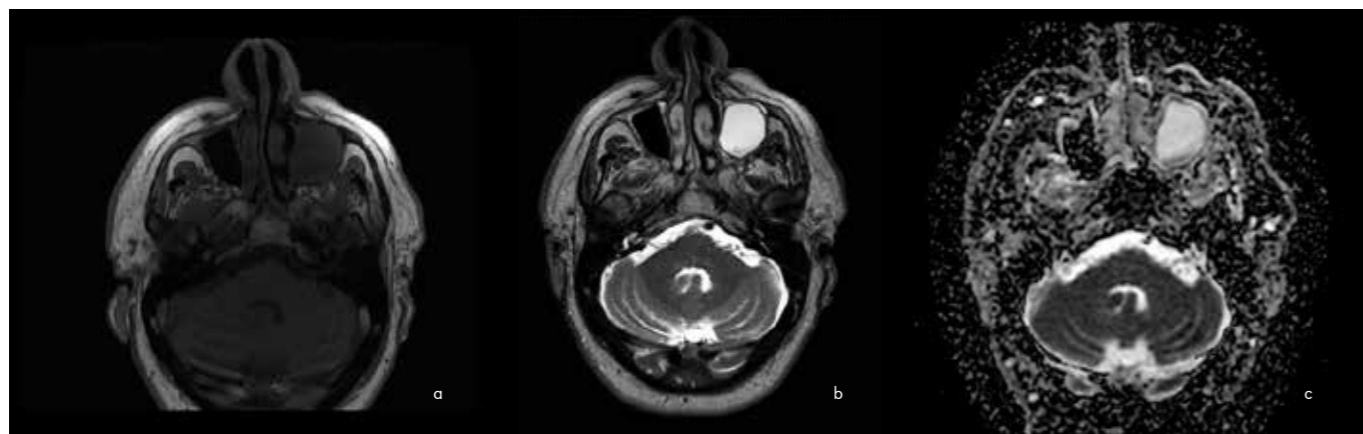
Magnetic resonance imaging taken on 07/12/2020 showing axial views a) Isosignal on T1-weighted b) Hypersignal on T2-weighted c) Heterogeneous hypersignal on ADC
